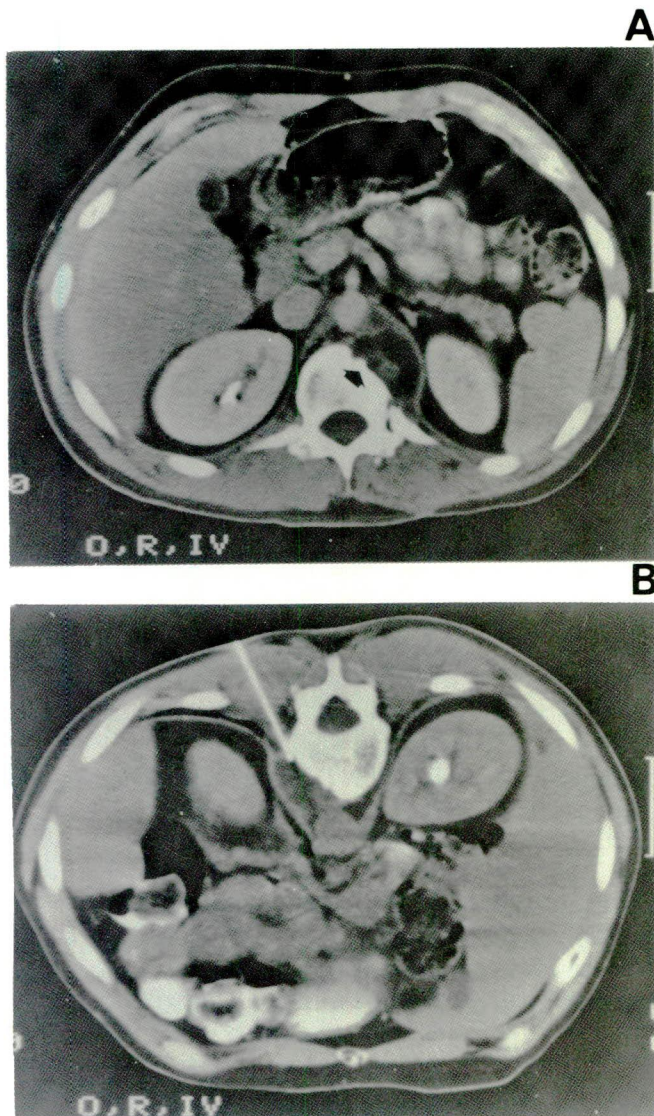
CT guided biopsy of the lymph nodes. 31-year-old male with mixed germ cell tumor of the testicle (Embryonal carcinoma, EST and mature-immature teratoma), status postchemotherapy. A. CT scan shows low density left retrocrural mass resulting in bone destruction (arrow). B. CT scan with the patient in the prone position shows the biopsy needle in place. Biopsy revealed mature teratoma.
